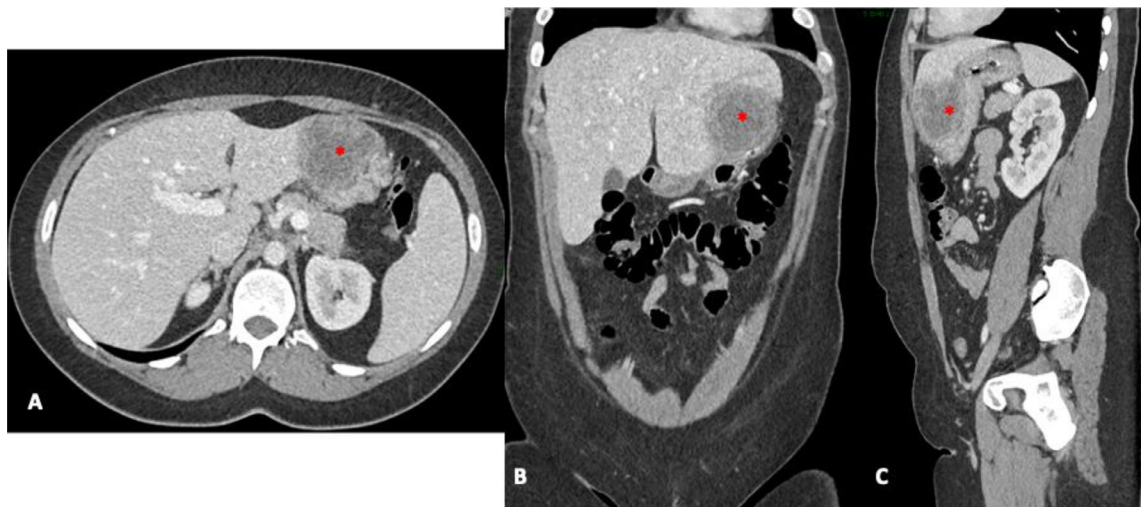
Axial (A), coronal (B), and sagittal (C) contrast-enhanced abdominal CT, demonstrating a round ill-defined hypodense lesion in the left hepatic lobe (red asterisk).
